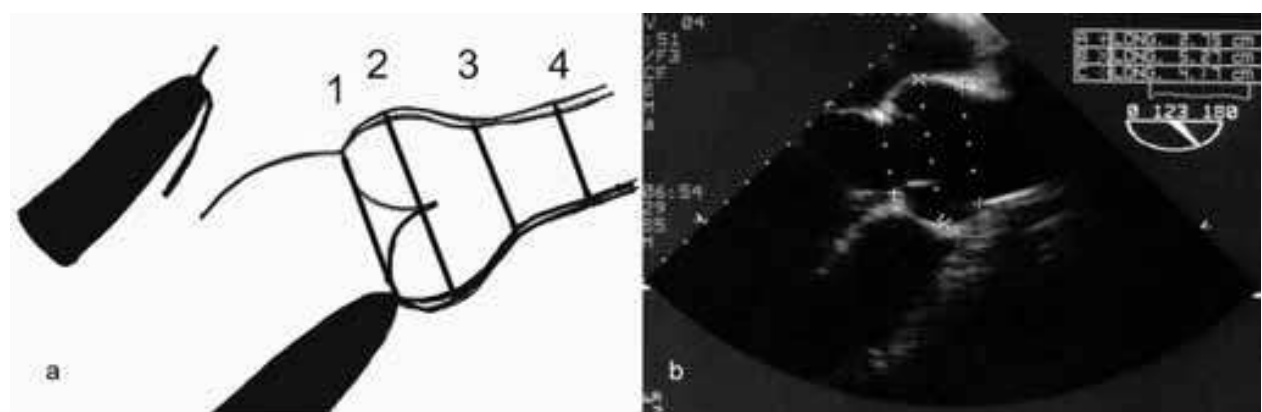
Echocardiographic measurements of aortic root diameters, in long-axis. 1) Aortic annular base diameter (internal diameter), 2) Sinuses of Valsalva (external diameter, from leading edge to leading edge), 3) Sino-tubular junction (external diameter, from leading edge to leading edge), 4) Ascending aorta (external diameter, from leading edge to leading edge)
